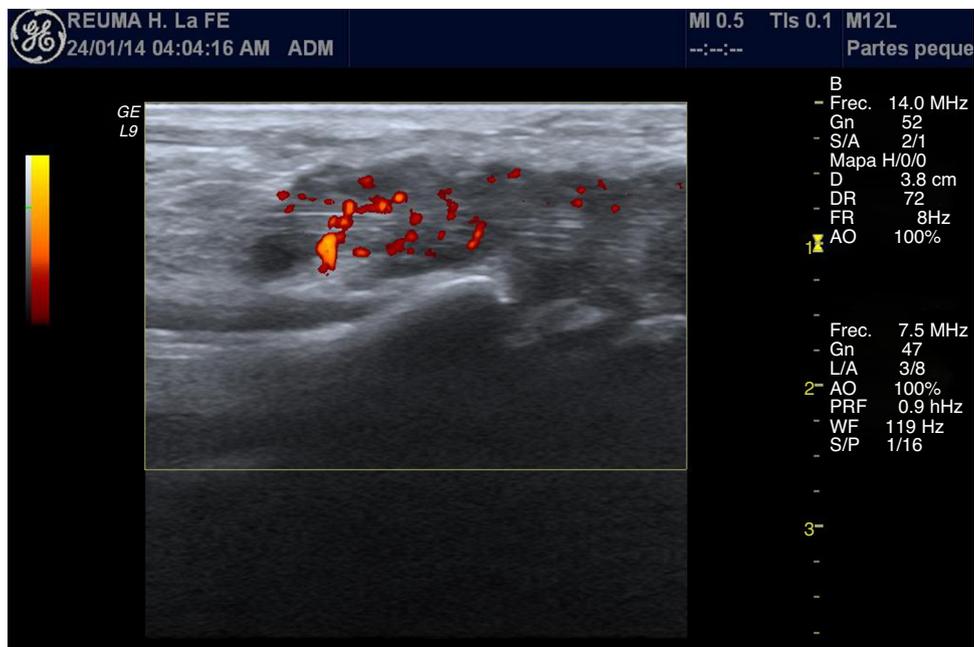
Longitudinal view of the palmar radiocarpal joint, in which the flexor tendons of the wrist are appreciated. A hypoechoic thickening of the synovial sheaths of the tendons is highlighted, corresponding to tenosynovitis with marked synovial hypertrophy and a pathological Doppler signal, which shows an increase of normal vasculature.
